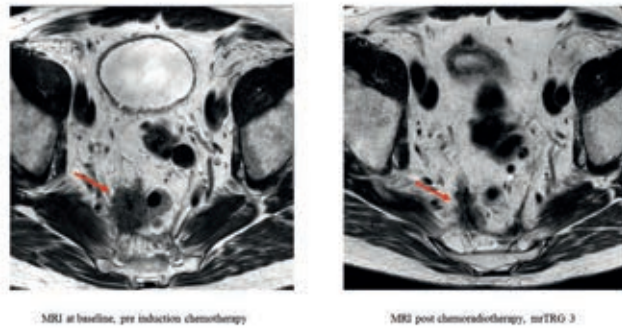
MRI at baseline and post chemoradiotherapy showing a moderate radiological response (i.e. mrTRG 3). In this case, restaging was performed > 7 weeks
